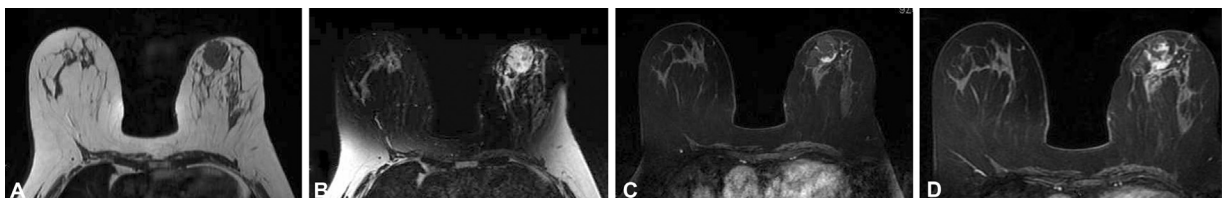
The lesion appears hypointense on T1-weighted images (A), heterogeneous hyperintense on T2 fat-saturated images (B). On dynamic postcontrast evaluation, heterogeneous enhancement of the mass seen with dilated vessel within as well as on the periphery of the lesion. Early (C) and delayed postcontrast images (D).
